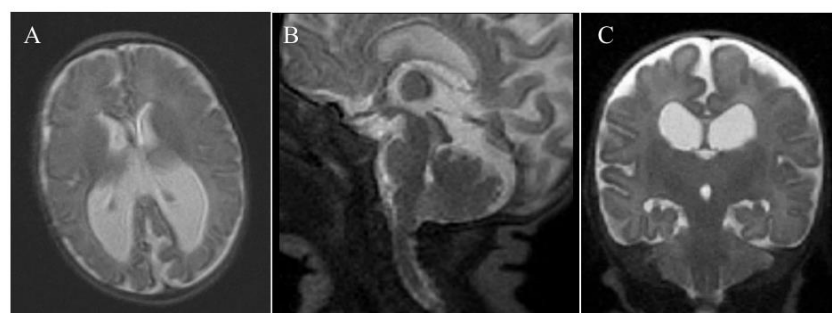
MRI at term-corrected 41 weeks A) axial T2 showing presence of colpocephaly in the occipital horns bilaterally B) mid-sagittal T2 showing tectal beaking, minimal hindbrain herniation C) coronal T2 showing ventriculomegaly stable compared to prior head ultrasounds, preserved extra-axial spaces and minimal cerebellar tonsillar descent.
